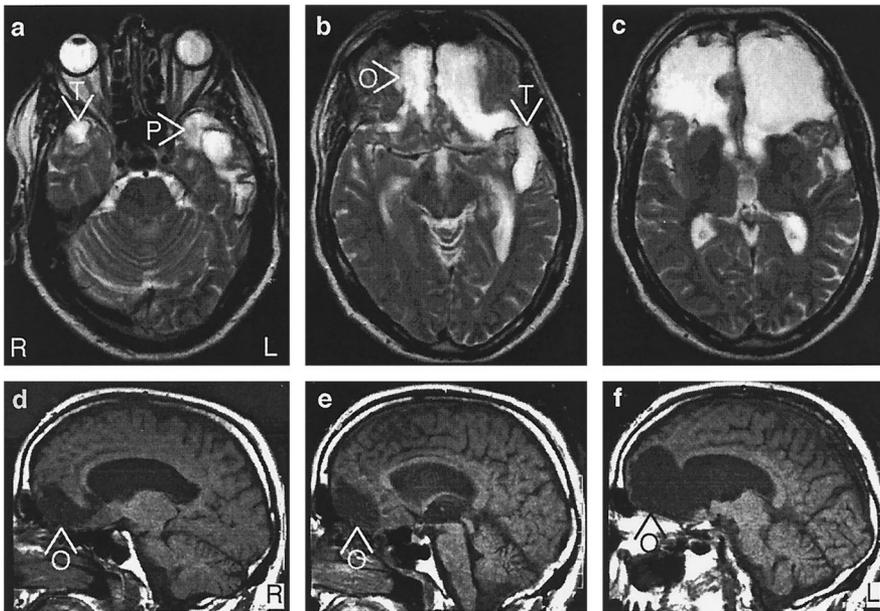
Continued confabulator (Patient 8), MRI after 3 years (a–c, axial T2; d–f, sagittal T1-weighted scan) shows extensive orbitofrontal damage (b–f), which reaches so far dorsally as to interrupt thalamo-prefrontal connections (c, f). Bilateral damage of the temporal pole (a, b) and extensive left perirhinal damage (a) are seen. The basal forebrain appears intact, but atrophied (b, e). O = orbitofrontal cortex; T = temporal pole; P = perirhinal cortex.
